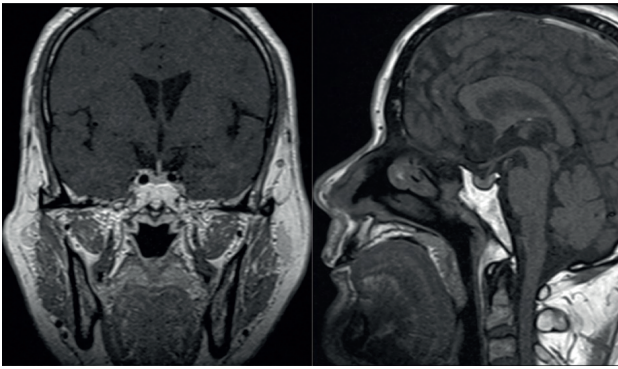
The proband underwent plain and enhanced magnetic resonance imaging of the pituitary gland. No abnormal signals were detected in the pituitary gland, and the pituitary stalk was centrally located. No abnormalities were observed in the morphology or signals of the optic chiasm and bilateral internal carotid arteries. On enhanced scanning, the enhancement of the pituitary tissue was relatively uniform and consistent, with no evidence of abnormal enhancement.
